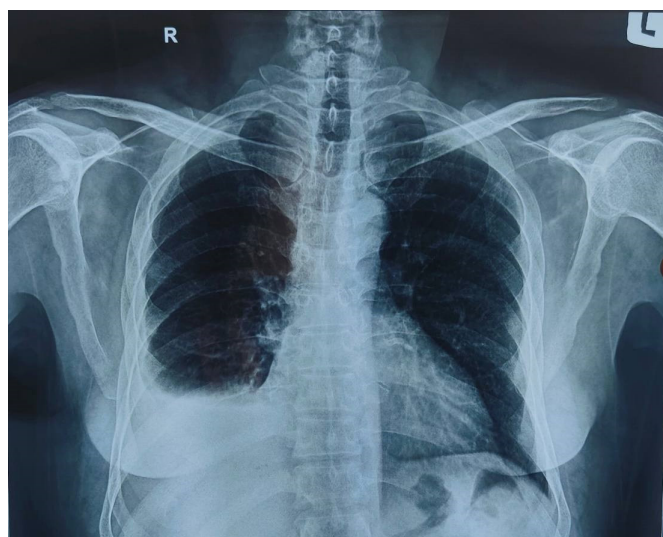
Chest X-ray of the patient showing right-sided pleural effusion.
